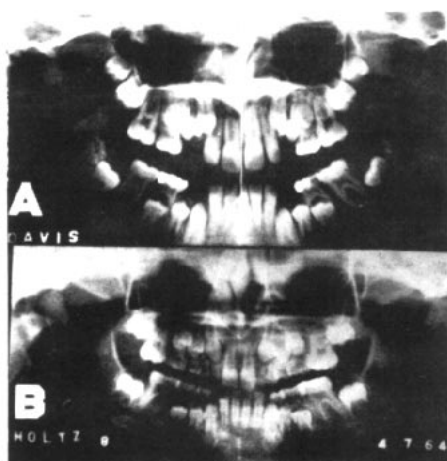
Panoramic radiographs taken with Panorex (A) and Orthopantomograph (B) during mixed dentition. Problems of space adequacy, tooth size, root resorption, direction of eruption, status of third molars, etc., are visualized with the aid of panoramic radiography. Such records are particularly valuable for serial extraction.
